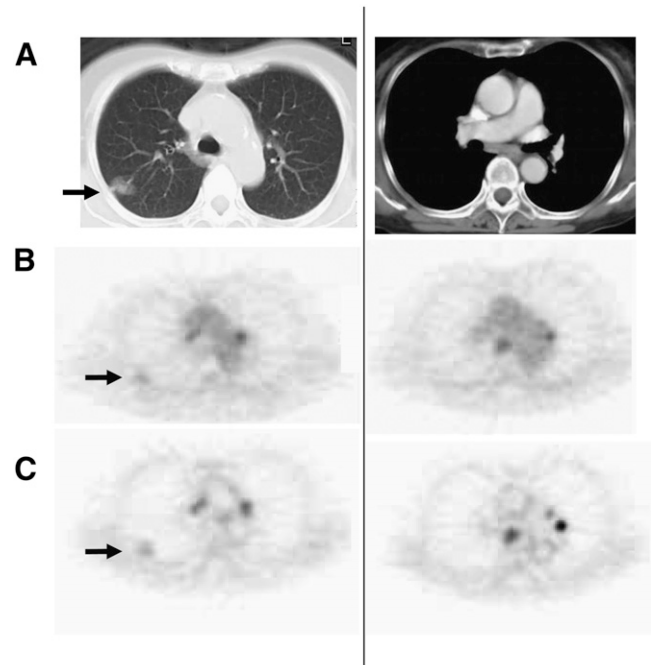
Representative case of adenocarcinoma and sarcoid reaction of mediastinal lymph node swelling: chest CT (A), early imaging (B), and delayed imaging (C). PET showed ^{18}F -FDG uptake in primary tumor (early SUV = 1.81, delayed SUV = 2.02) (arrows) and focal uptake in mediastinal lymph nodes (lymph node 3: early SUV = 2.91, delayed SUV = 4.2; lymph node 7: early SUV = 3.89, delayed SUV = 5.086). RI SUV in primary tumor was 11.6%; however, RI SUVs in these lymph nodes were much higher (30.8%–44.3%). These nodal uptakes were confirmed at surgery as sarcoid reaction.
